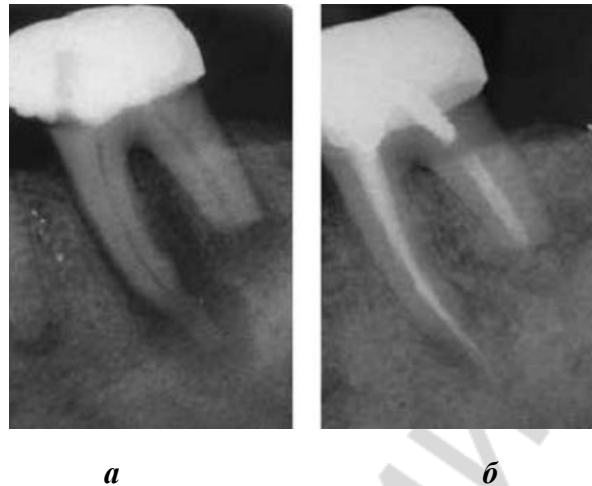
Radiograph showing external inflammatory root resorption before treatment (a) and 6-month follow-up after root canal therapy (b)
